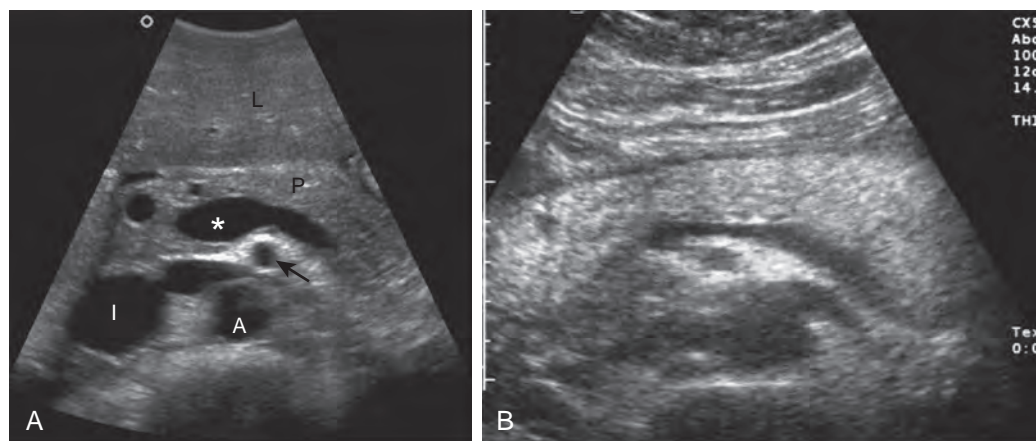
Normal pancreatic anatomy on ultrasound.
